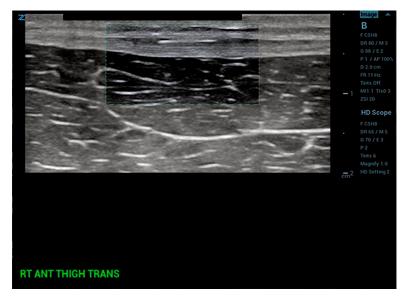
Point-of-care ultrasound of the right anterior thigh demonstrating a foreign body in transverse view.
